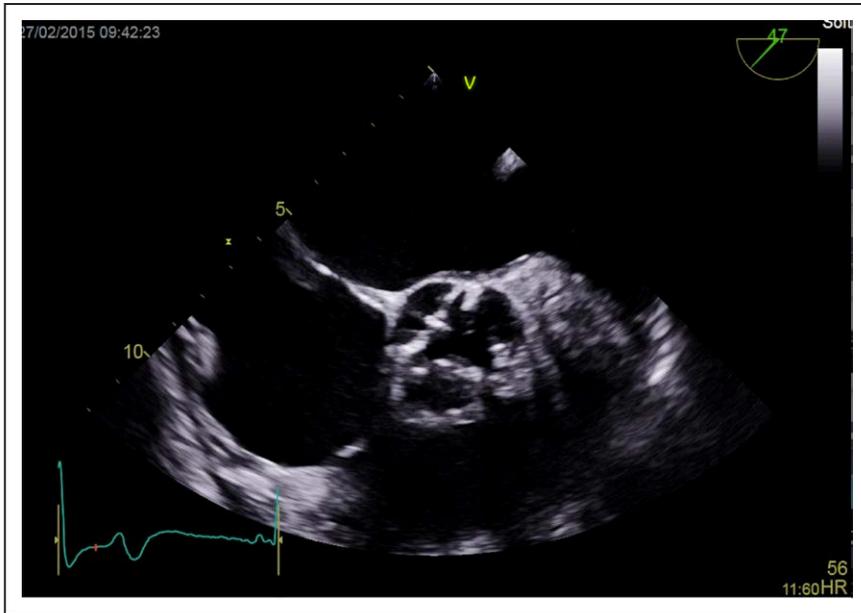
Transesophageal echocardiogram: mid-esophageal short-axis view of the aortic valve opening consistent with moderate aortic stenosis.
